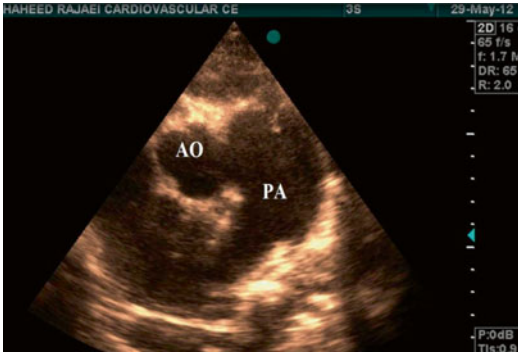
Transthoracic echocardiography in short axis view showing “T” artifact at the edges of the defect suggestive for aortopulmonary septal defect that was confirmed by color flow imaging (Video 52.1). AO aorta, PA Pulmonary artery
